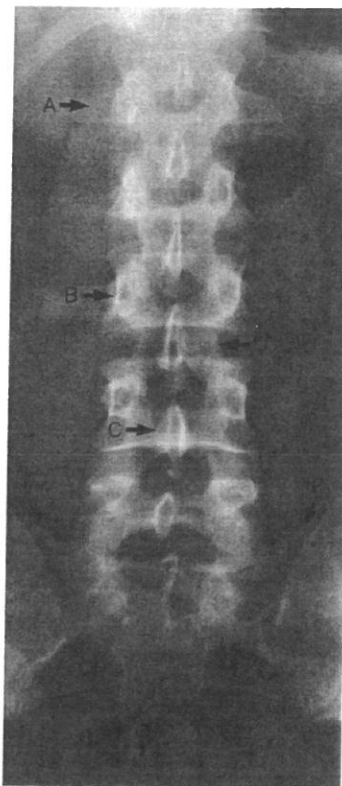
Roentgenogram of normal lumbosacral spine. A, transverse process. B, pedicle. C, posterior spinous process. D, lamina. E, sacrum.
